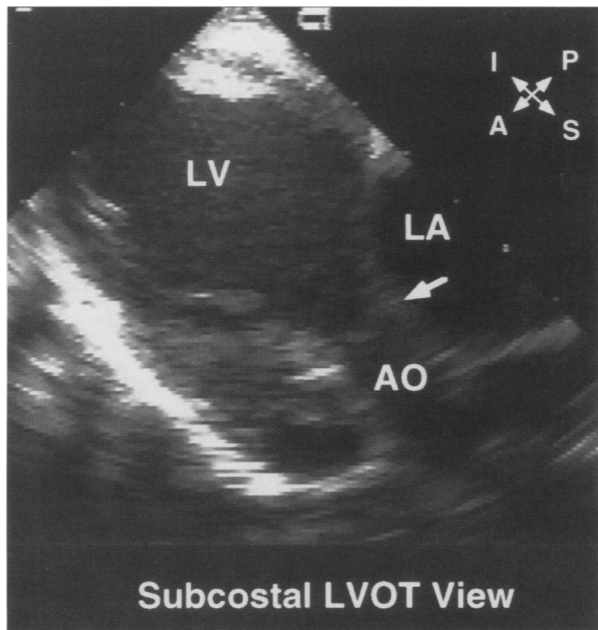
Longitudinal transgastric (subcostal) view of a normal left ventricular outflow tract (LVOT). This view shows the benefit of longitudinal imaging for evaluating the LVOT in pediatric patients. This plane provides a favorable angle for Doppler study of the LVOT, aortic valve (arrow), and ascending aorta (AO). The mitral valve can also be evaluated from this view, as well as from the LV–LA 2-chamber longitudinal view (not shown).
